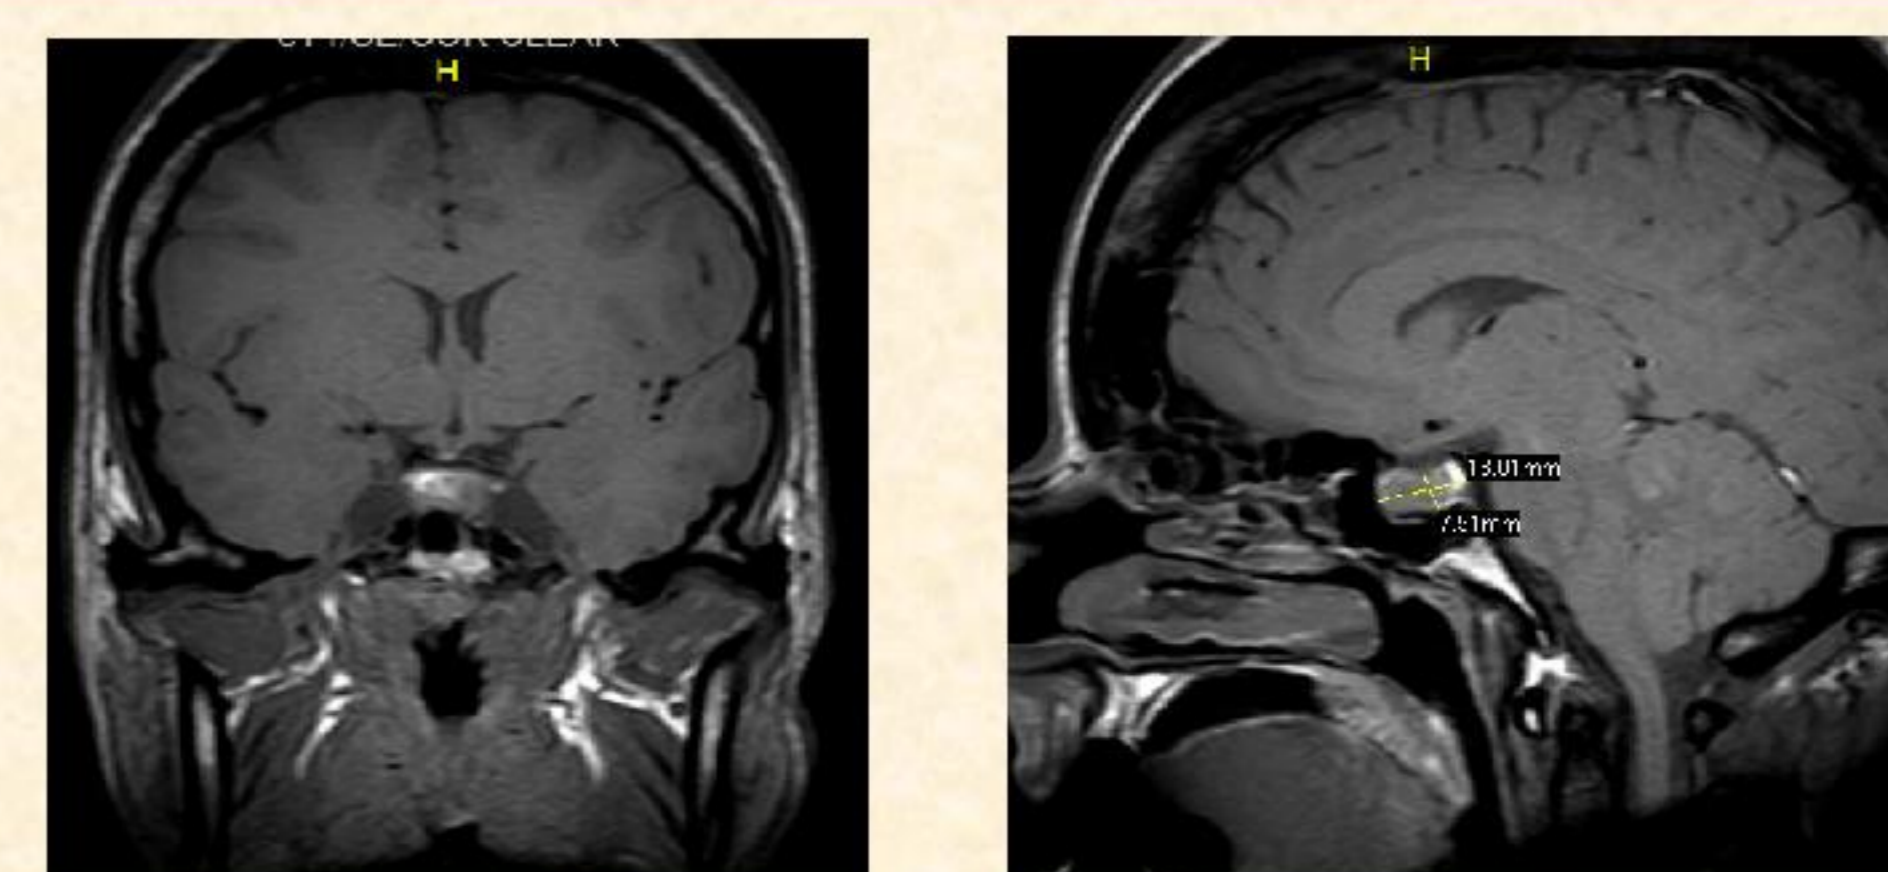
Pituitary MRI after 8 months of treatment
